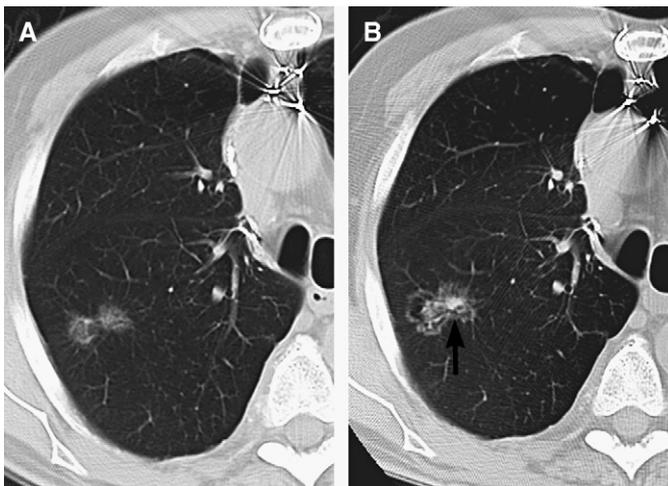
An 81-year-old man with non-small cell lung cancer. (A) CT scans with two separate foci of ground glass density (nonsolid) in the right lung. This nonsolid appearance is frequently seen in bronchioalveolar carcinoma. (B) Same levels in the right lung 1 year later. The tumor densities have increased in size and have developed small central solid cores (arrow), suggesting evolution to more aggressive adenocarcinoma in the central region.
